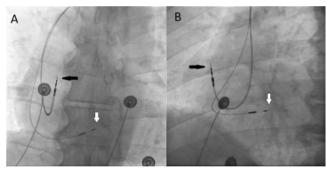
Posteroanterior (A) and left anterior oblique (B) chest x-ray images showing final lead position (black arrow – atrial lead; white arrow – His bundle lead).
